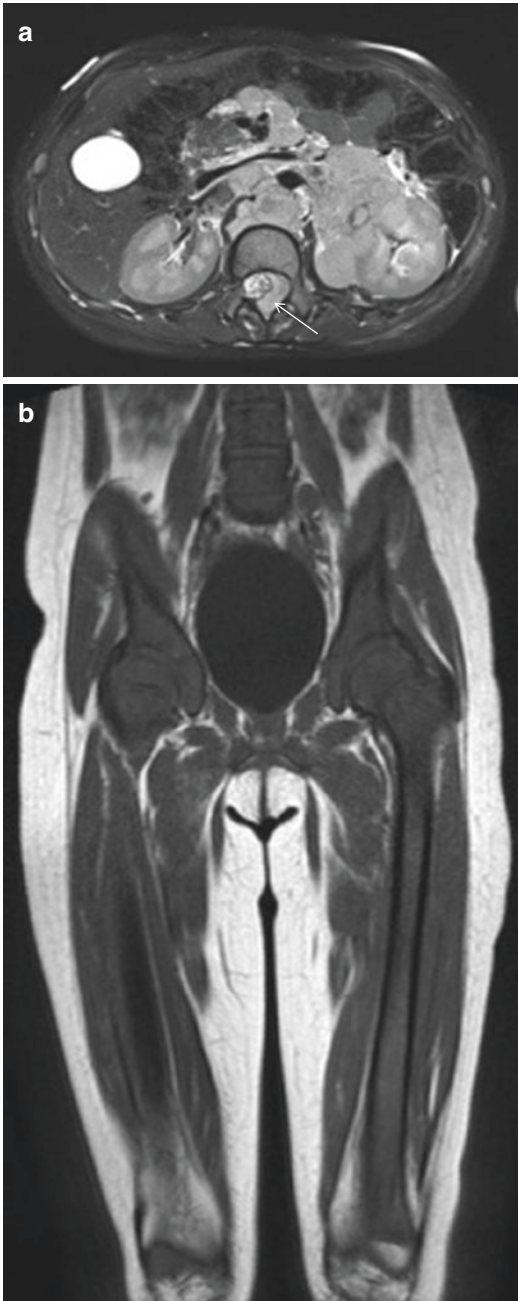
A 4-year-old girl presenting with acute urinary retention. (a) On this fat saturated T2-weighted image a lobulated neuroblastoma with an intraspinal component (*white arrow*) is shown. (b) On this coronal T1-weighted image of pelvis and femora, the bone marrow is diffusely hypointense due to tumoral infiltration
